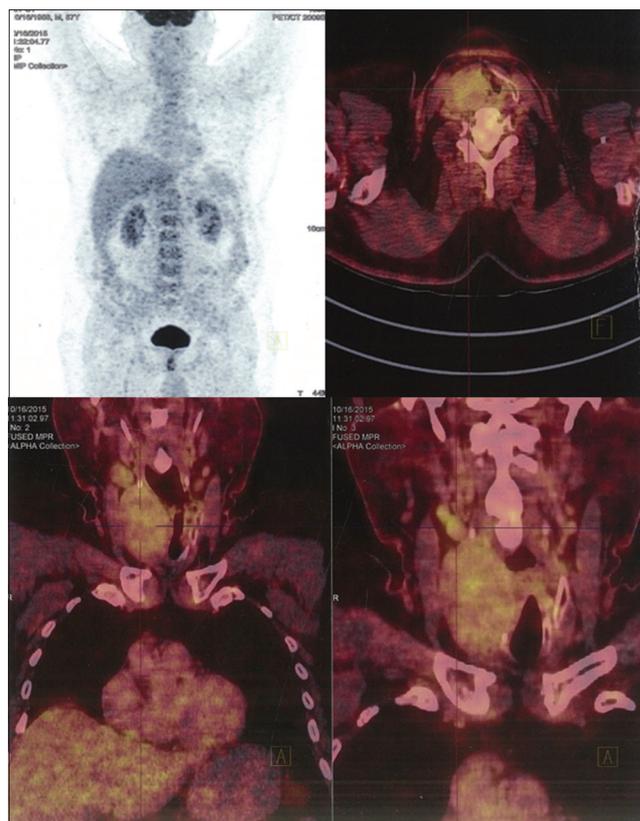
Positron emission tomography/computed tomography scan showing a thyroid mass with fluorodeoxyglucose uptake (SUV_{max}) of 3.5.
